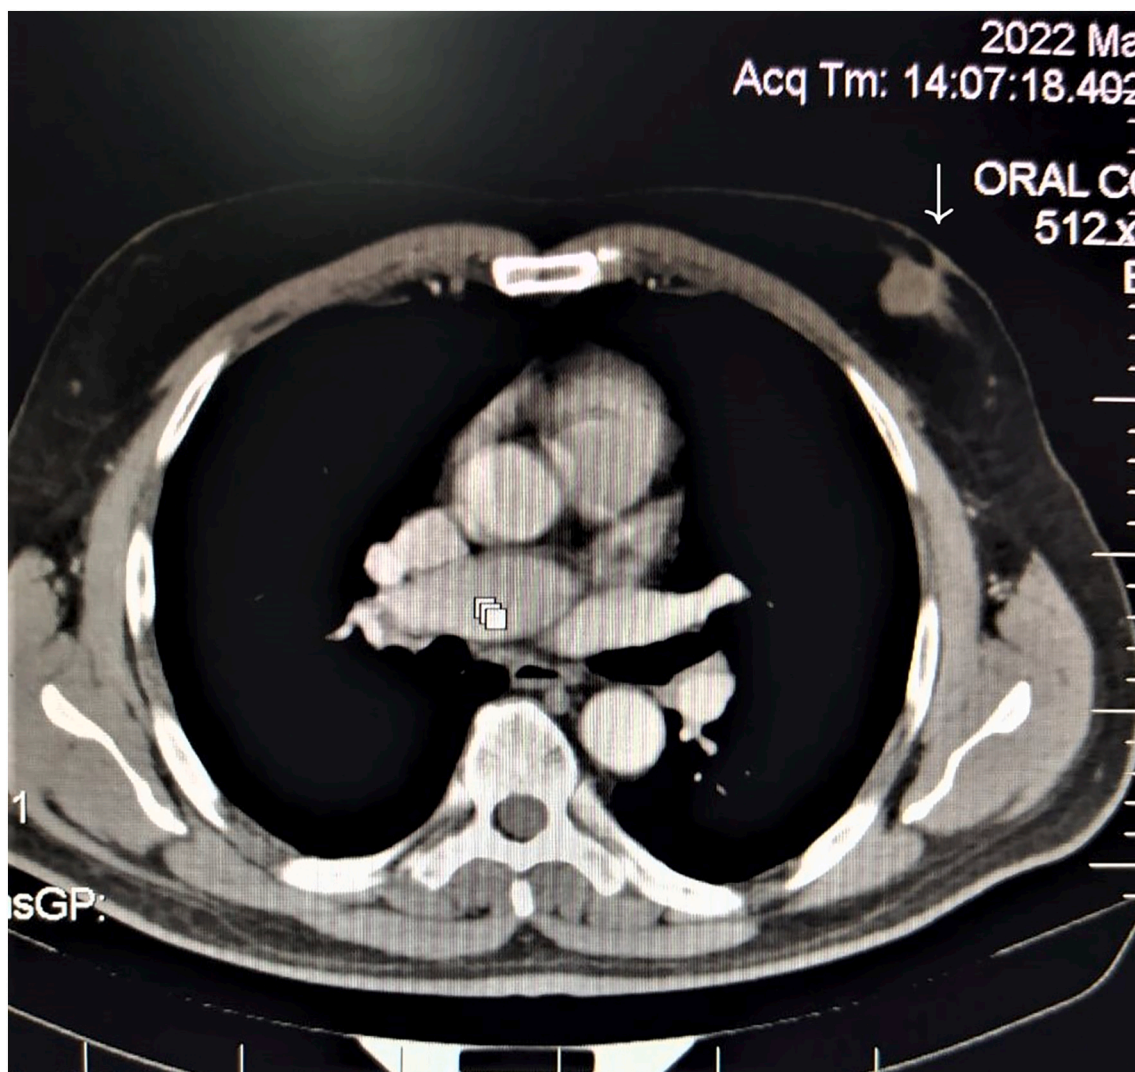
Preoperative CT scan cross-sectional view, revealed a primary left breast retro-auricular mass measuring approximately (2.2 × 2.5 cm) with no evident lymphadenopathy (Arrow).
